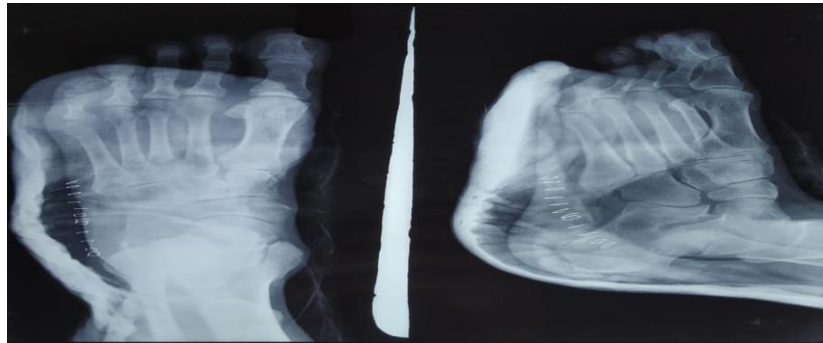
Immediate postoperative x-ray- anteroposterior and oblique view
